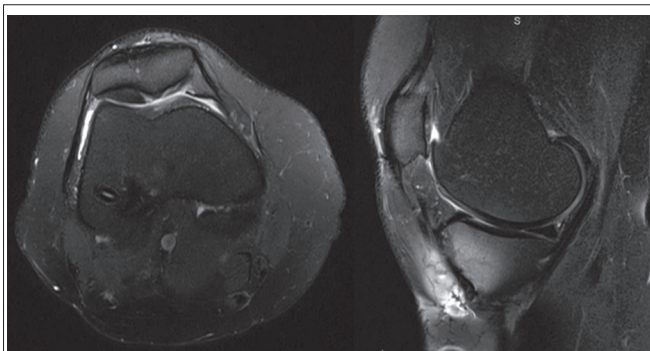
Magnetic resonance imaging showing full-thickness cartilage loss. Note cartilage delamination extending from the median ridge of the right patella to the lateral patella facet, with moderate and full-thickness cartilage loss along the central and medial trochlear surfaces. Left: Right knee, pre-operative, axial T2 fat saturation (FS) view. Right: Right knee, pre-operative, sagittal T2 FS view.
